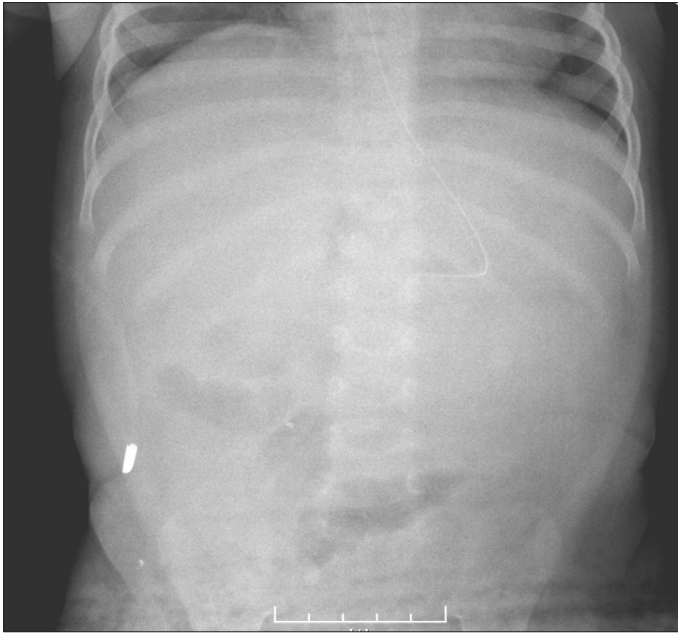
[Plain roentgenogram]. Absence of radio-opacity after the removal of drainage catheter
